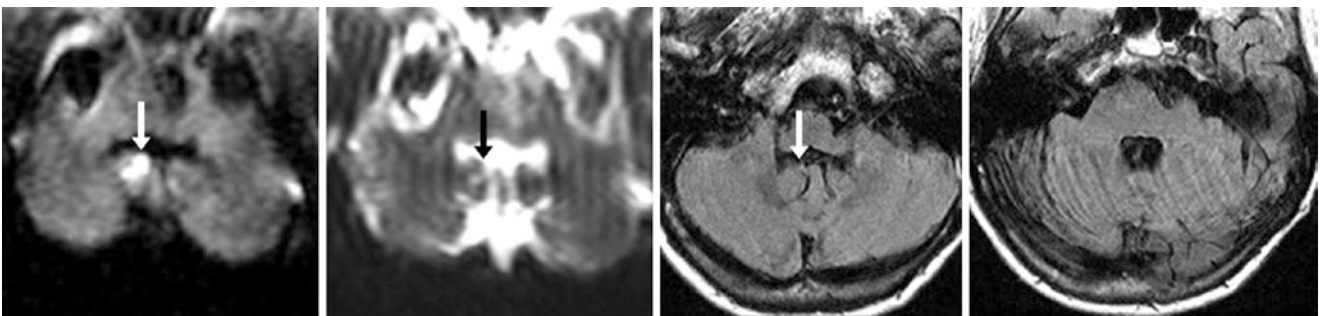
In an 81-year-old with 1.5 T MRI, motion causes focal hyperintensity (*arrows*) in the right hemis cerebellum on DWI (*left*). DWI ($b=0$) shows blurred curvilinear artifacts from motion (*left mid-*
